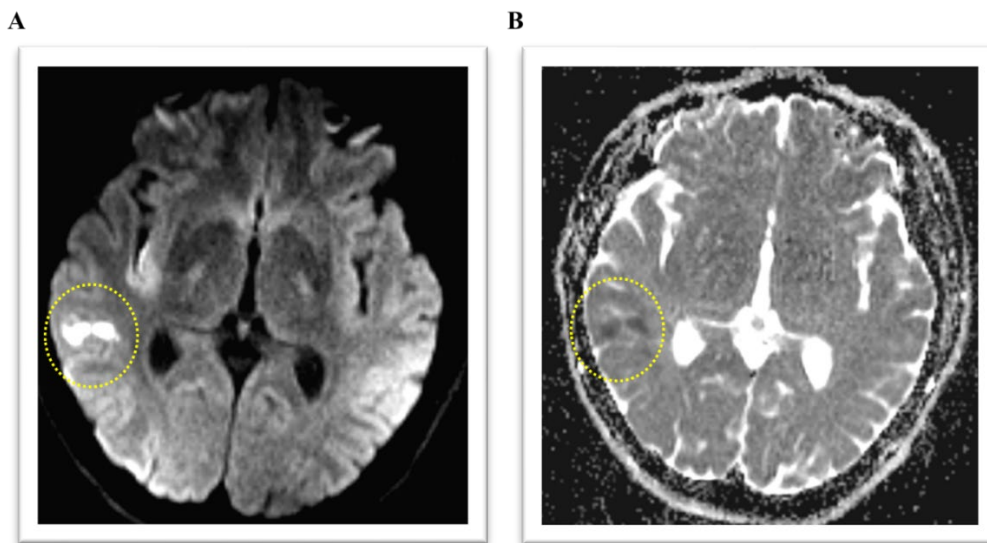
Brain MRI of Case 2 (A) Diffusion and (B) ADC scans showing right MCA stroke and right MCA M1 occlusion (as high lighted by yellow dotted circle).
